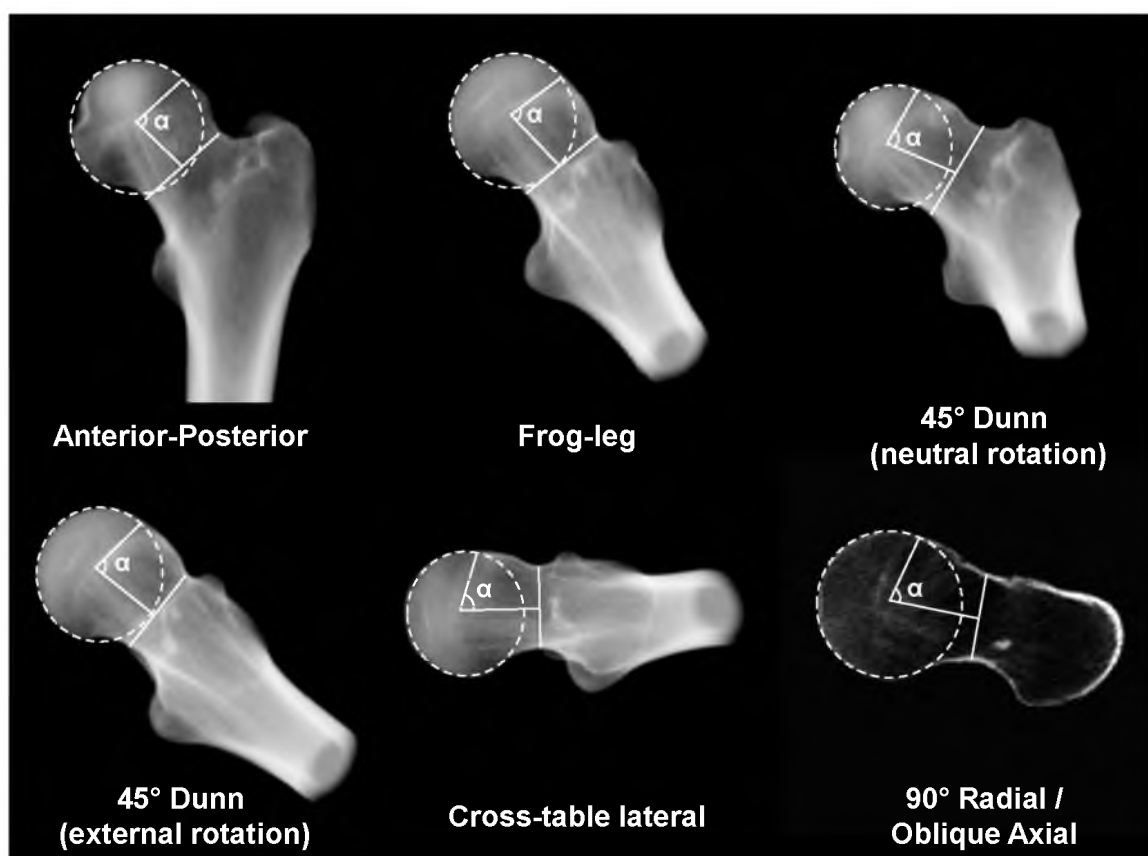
Representative DRRs and 90° Radial CT / oblique axial view with alpha angle (α) outlines for a single cam FAI patient.
